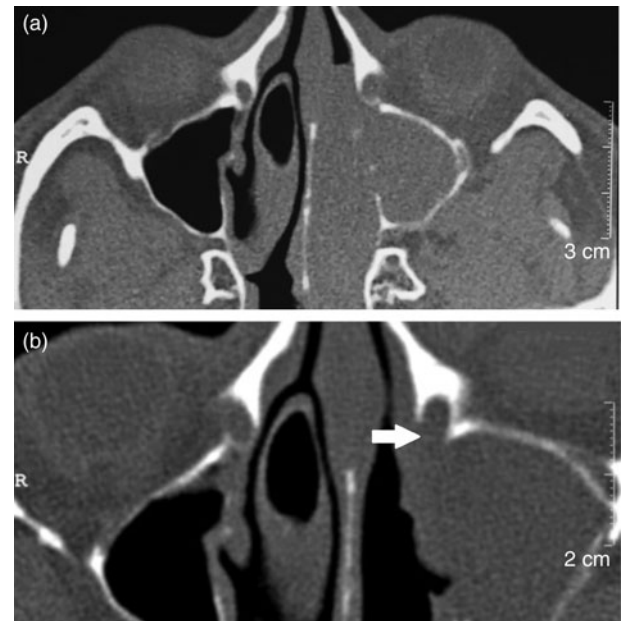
Axial computed tomography images reconstructed in the bone window setting. (a) Pre-operative scan showing an intact bony nasolacrimal duct on the left side, but the bony wall of the right nasolacrimal duct is thin and surrounded by disease process. (b) Post-functional endoscopic sinus surgery image showing the absent posterior-medial wall of the left bony nasolacrimal duct (white arrow). R = right
